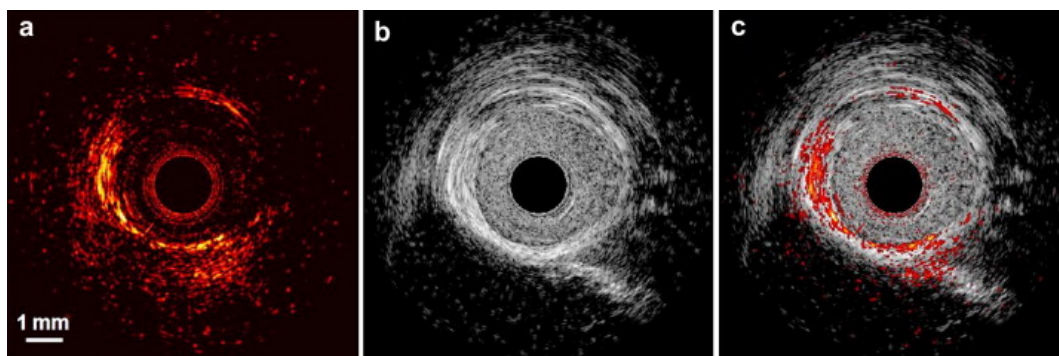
In vivo* IVPA/IVUS imaging in Watanabe heritable hyperlipidemic rabbit abdominal aorta. (A) PA imaging was able to provide lipid characterization, (B) while ultrasound provided structural information. By overlaying these two images plaque accumulation can be resolved within the intimal layer. Figure adapted from Wang et al.⁹⁹.
